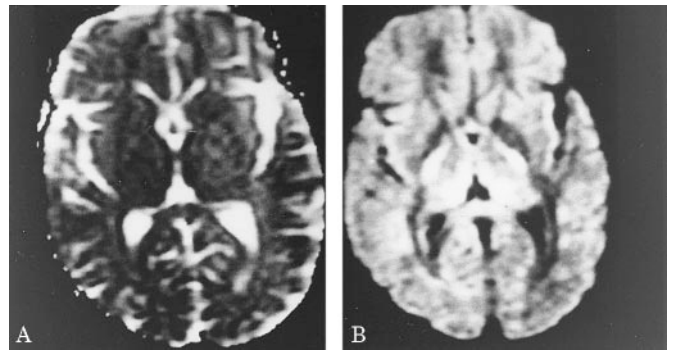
(A) DWI shows hyperintensity in the dorsomedial nuclei of the thalami without mass effect. MR of Patient 1 at the level of the basal ganglia. (B) ADC map revealed that these regions become hypointense, confirming restrictive diffusion. MR of Patient 1 at the level of the basal ganglia.
